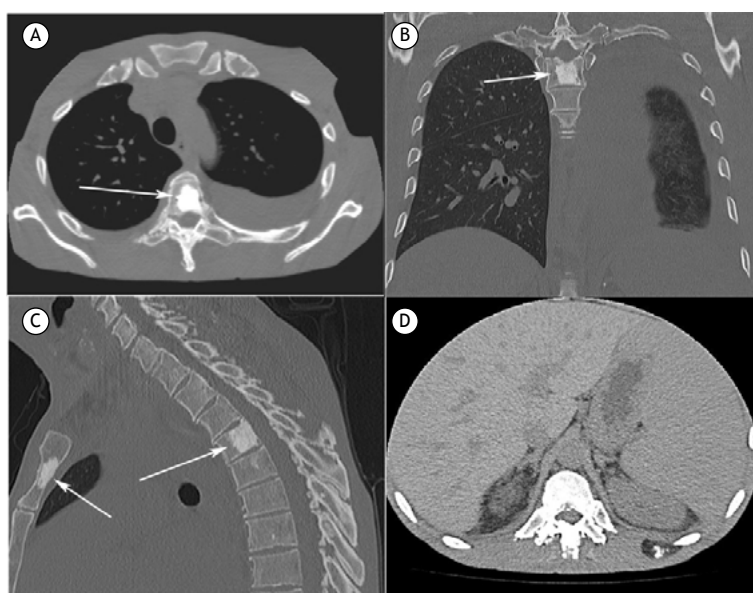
Computed tomography performed with mediastinal window settings and axial (A), coronal (B), and sagittal (C) reconstruction showing left pleural effusion. Note also the presence of multiple sclerotic lesions in the vertebral bodies and sternum (arrows). (D) Axial view of the upper abdomen demonstrating hepatosplenomegaly.
